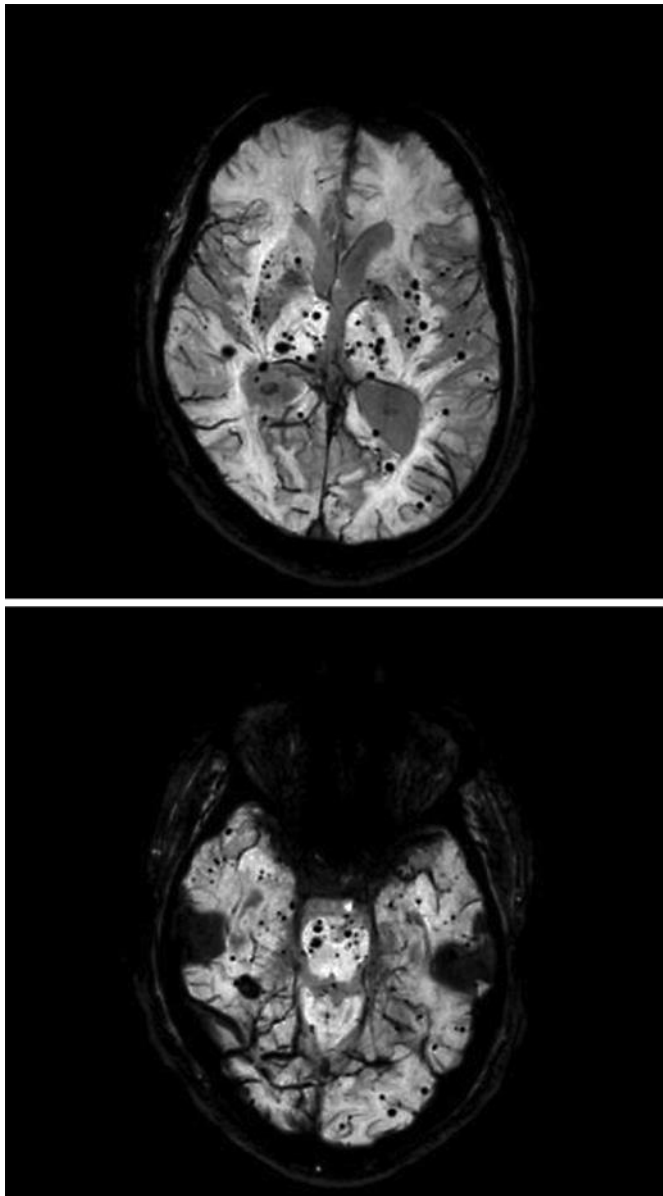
MRI brain showing multiple extensive foci of susceptibility on gradient sequence predominantly centered within the basal ganglia, thalami, brainstem, and deep and subcortical white matter of both cerebral and cerebellar hemispheres.
